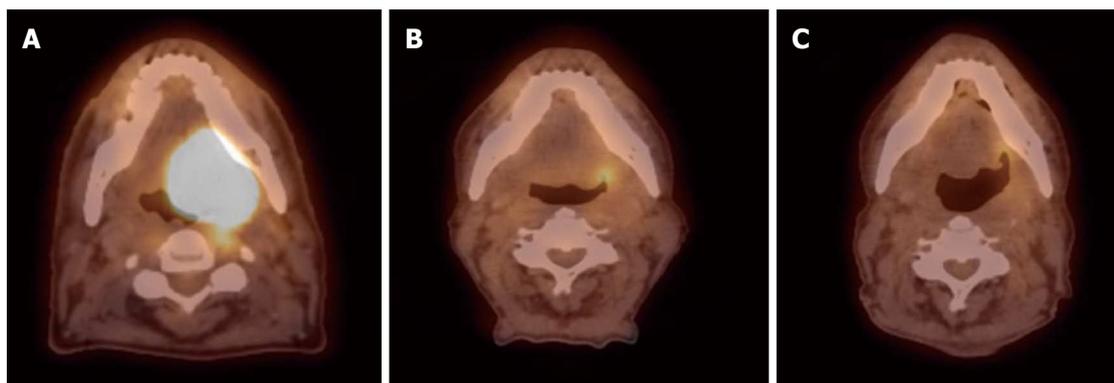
Sixty-six year old male was diagnosed with squamous cell carcinoma of the left base of tongue T4aN1M0. He received external beam radiation therapy (70 Gy in 35 fractions) with concurrent cisplatin 100 mg/m² (3 cycles). Positron emission tomography/computed tomography scans were done pre-treatment (A) and at 3-mo (B) and 8 mo (C) post-radiation therapy. Follow-up images show good response to treatment with sustained response at least 8 mo from treatment.
